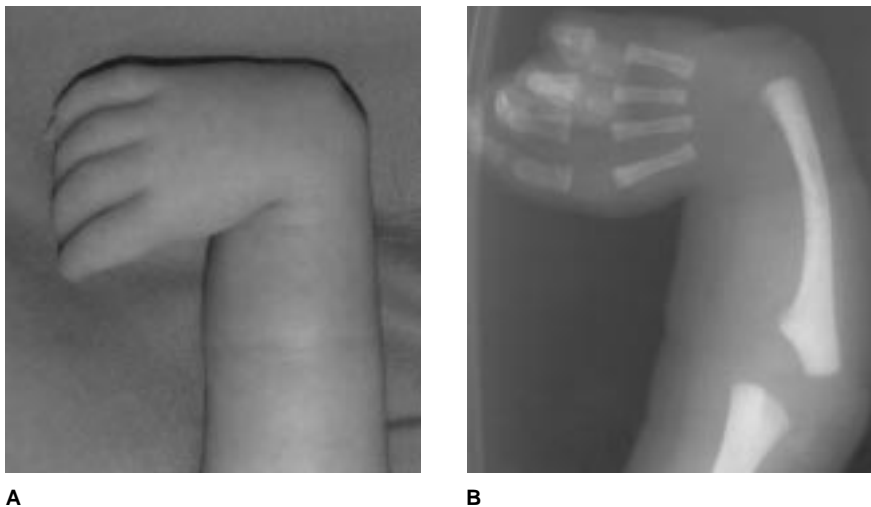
Type 4 radial club hand in a 2-month-old boy. A, Clinical appearance. B, Radiographic appearance.
